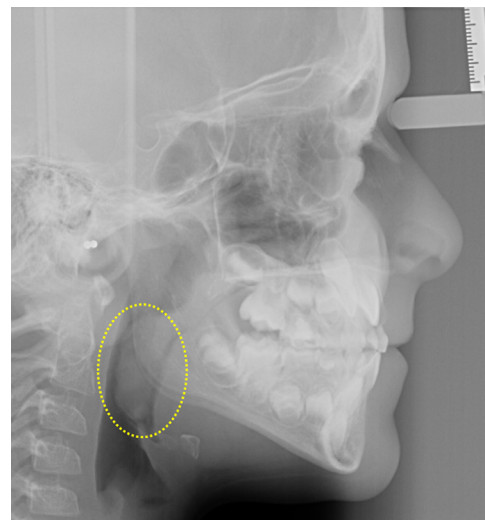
Lateral cephalometric radiograph of a 6-year-old boy. The circle in yellow denotes the hypertrophied tonsils almost blocking totally the pharyngeal airways.
